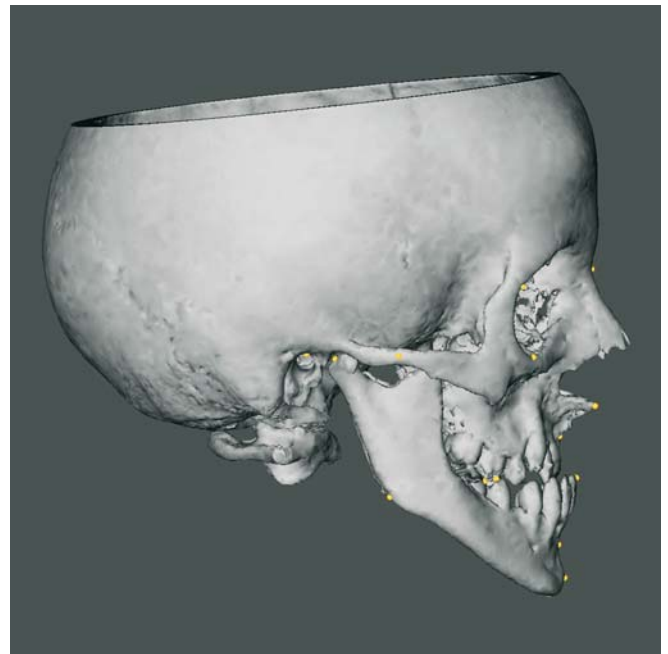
Supero-anterior displacement rotation of the mandible in an adult cleft patient. The forward and upward rotation of the mandible to meet the short midface causes mandibular protrusion. (3-D CT hard tissue surface representation, patient B.V.)
